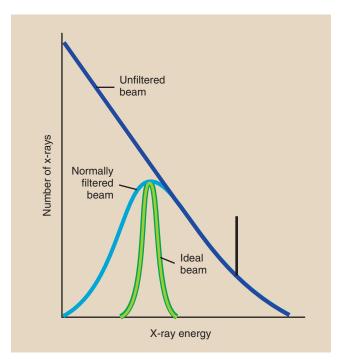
Filtration is used selectively to remove lowenergy x-rays from the useful beam. Ideal filtration would remove all low-energy x-rays.
